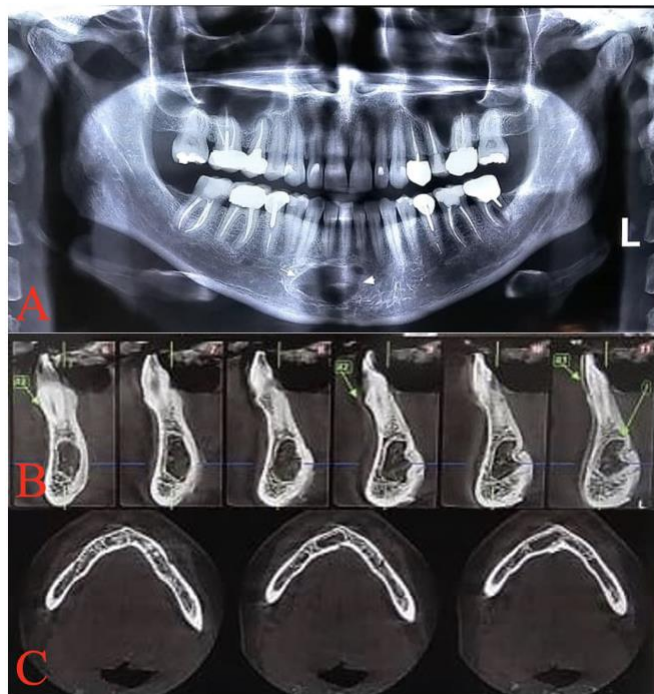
(A) A well-defined corticated unilocular radiolucency in the anterior of the mandible in panoramic radiography. (B and C) Serial axial and cross-sectional view of CBCT showed no expansion or perforation in mandible.
